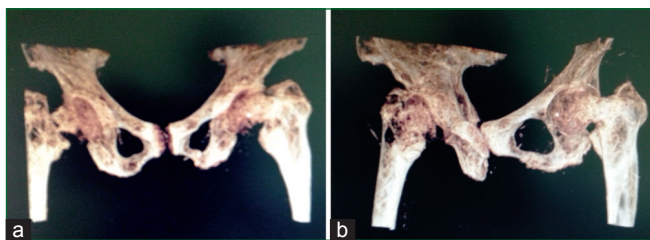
CT showing bilateral impacted neck of femur fracture
